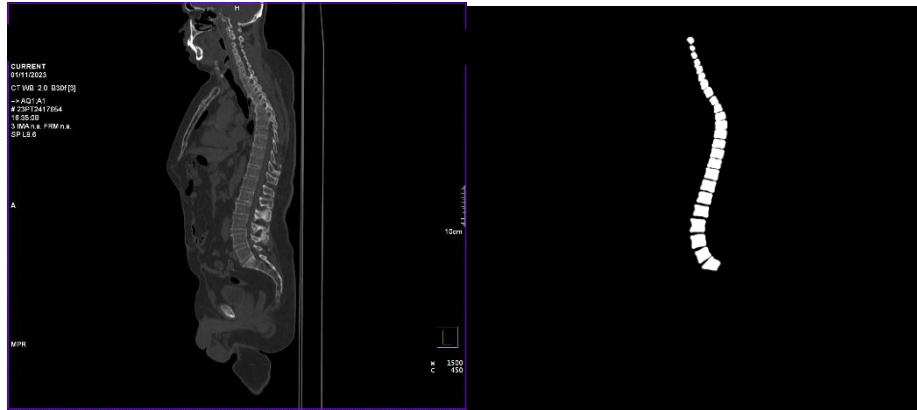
Patient's lateral CT scan and its manual labeling
